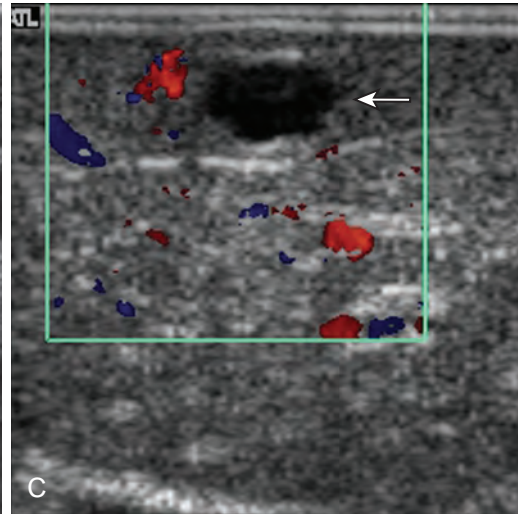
Use of intraoperative ultrasound in detecting more lesions in a 36-year-old woman with a hepatic lesion thought to represent an adenoma but with symptoms of pain. A. Intraoperative ultrasound reveals the large hypoechoic mass (arrow). B. An echogenic lesion characteristic of a hemangioma was also seen (arrow). C. An additional unsuspected small hypoechoic mass was also identified (arrow). The dominant lesion is again seen (arrowhead). The hypoechoic lesions were resected and found to represent hepatic adenomas removed because of the patient's symptoms.
